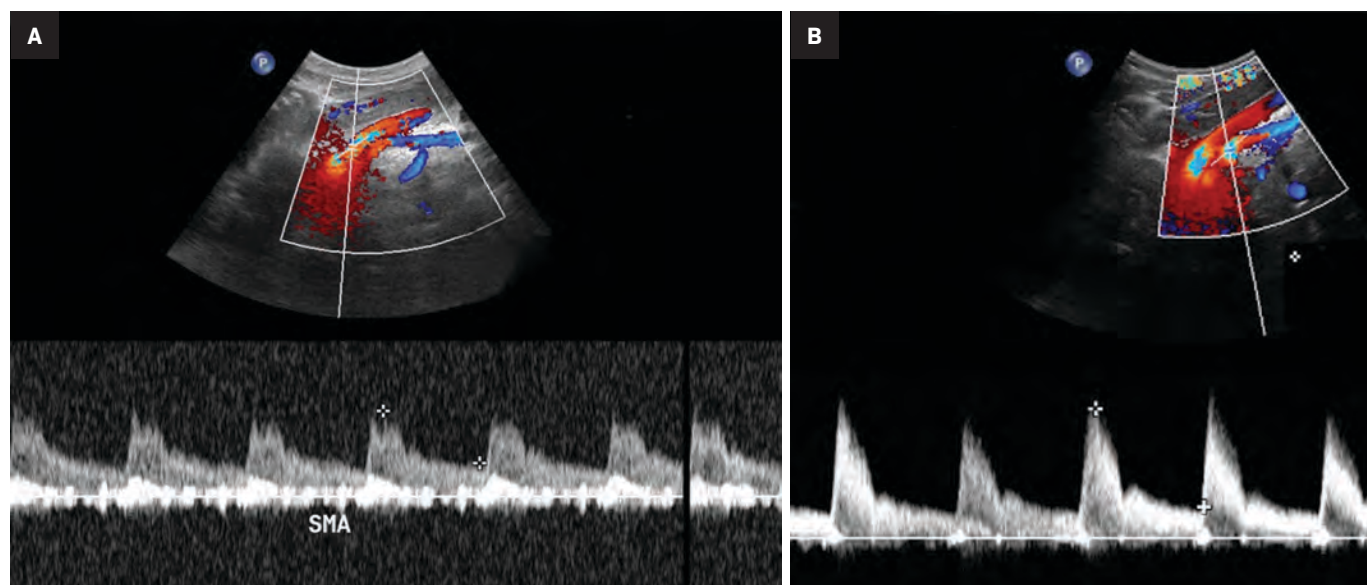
Fasting (A) and postprandial (B) duplex sonography of the SMA showing normal waveforms with continuous forward flow and a normal PSV of 160 cm/s in the fasting state and 328 cm/s in the postprandial state. This constitutes a normal postprandial rise in PSV (105%). However, this case was interpreted as SMA stenosis, with the impression of the ultrasound report reading, "Findings consistent with chronic mesenteric ischemia (greater than 70% stenosis)." Sagittal maximum intensity projection CT angiogram of the abdomen with intravenous contrast (C) performed for further assessment showed a widely patent SMA (arrow). Note the tortuous course of the abdominal aorta. The inclusion of postprandial imaging and rise in postprandial PSV resulted in confusion and misdiagnosis of SMA stenosis.
